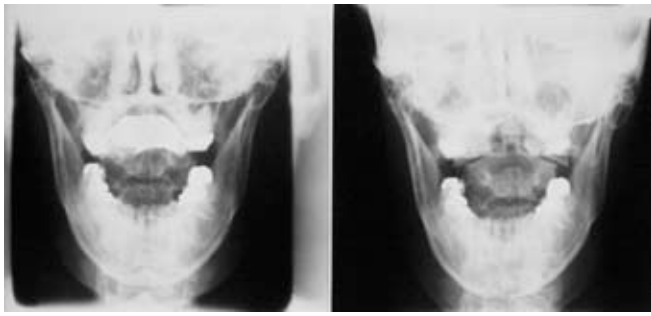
(a- left) Inadequate open mouth anteroposterior view, taken 2 days after the injury. (b-right) Open mouth anteroposterior view, taken 4 days after the injury. The repeat radiograph shows a total of 14mm of bilateral offset of the lateral masses, indicating an unstable Jefferson fracture.
